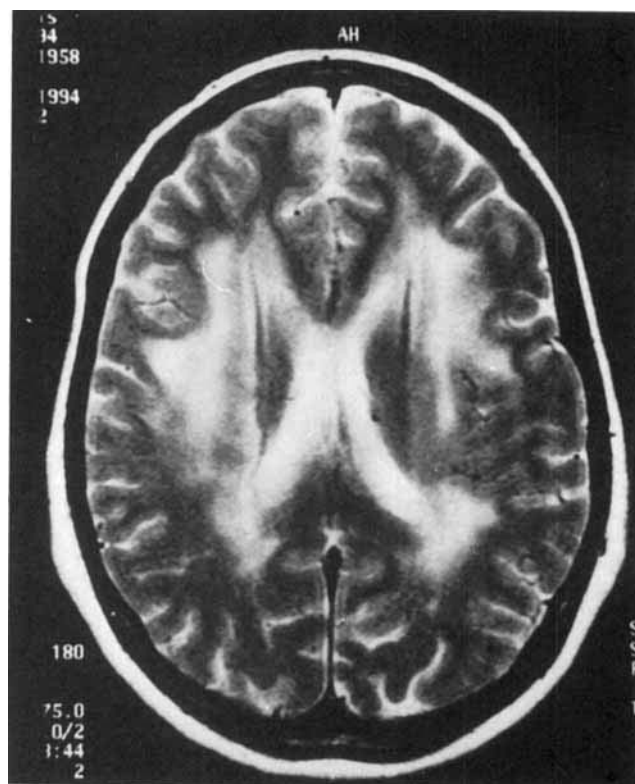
Cranial MR-imaging shows confluent, symmetric periventricular white matter hyperintensities on PD and T2-weighted studies and a slightly hypointensive signal relative to adjacent brain on T1-weighted studies in the same regions. Subcortical U-fibres were spared. No abnormal enhancement occurred after administration of a paramagnetic agent. Cortex and basal ganglia appeared to be normal in signal and morphology. No ventricular enlargement or mass effect were present.
